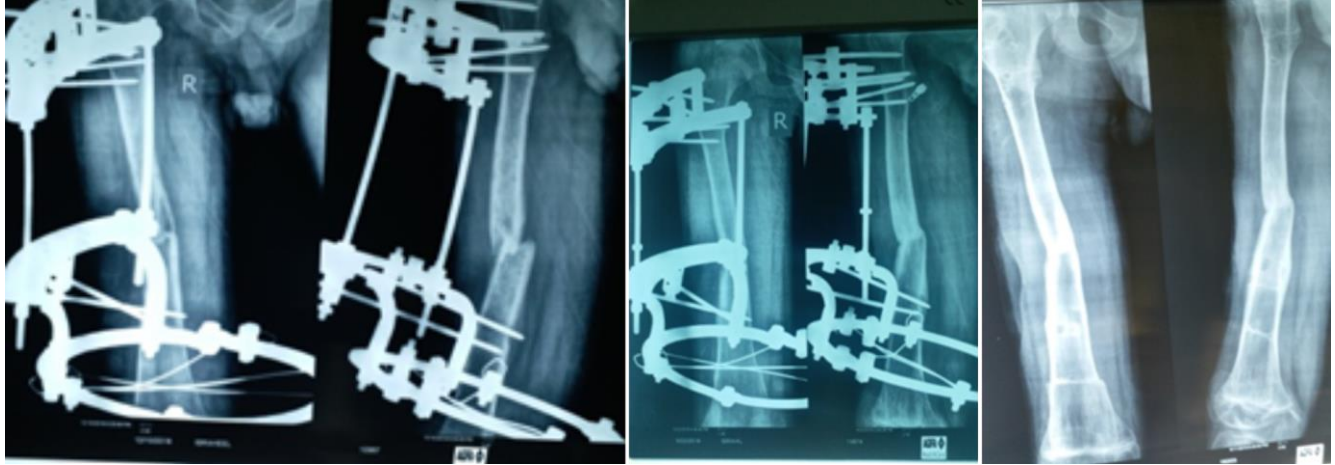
Fig IIA: Ilizarove applied to infected nonunion femur. Fig IIB: Follow up Xray. Fig IIC: Xray after union and Ilizarov removal
